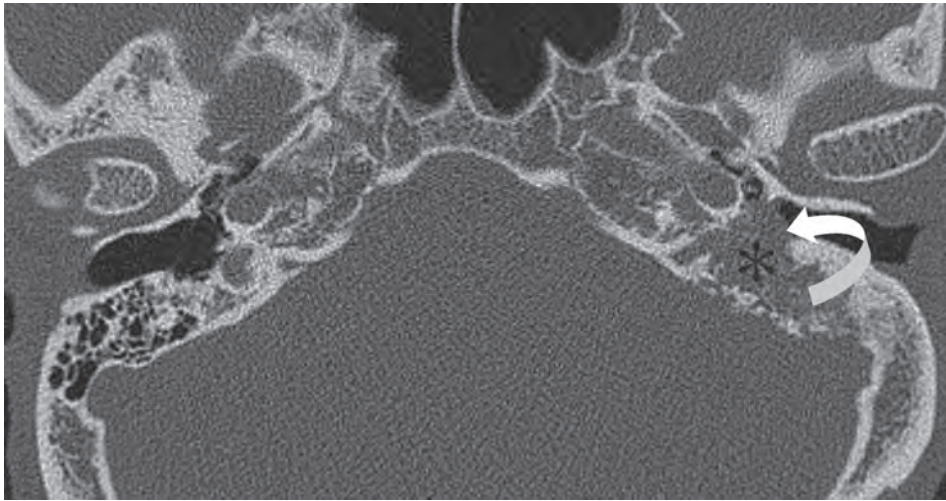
Axial plain CT scan in bone setting at the level of mastoids showing soft tissue lesion occupying the left mastoid air cells with loss of the expected bony trabeculae within (*). The soft tissue density within the mastoids has eroded the medial wall of the temporal bone extending into the external and middle ear canal (curved arrow).
